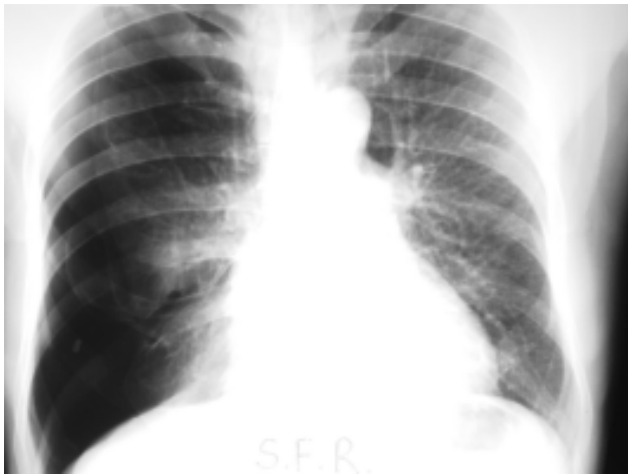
Right spontaneous hypertensive pneumothorax with evolution longer than 48 h in a COPD patient. Approximately 12 h after the drainage, the patient presented clinical features compatible with acute pulmonary edema. At the control X-ray, the presence of unilateral reexpansion pulmonary edema is noticeable, with predominant opacity at the right upper lobe, air bronchogram and cissural and pleural effusion.
